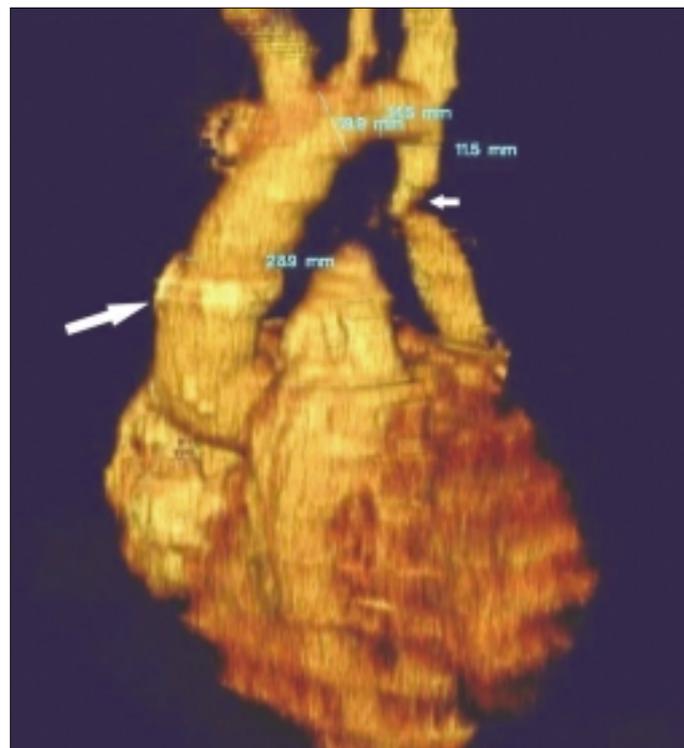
Multislice computed tomography shows aortic coarctation just below the left subclavian artery after ascending aorta replacement in sagittal cross-section view
